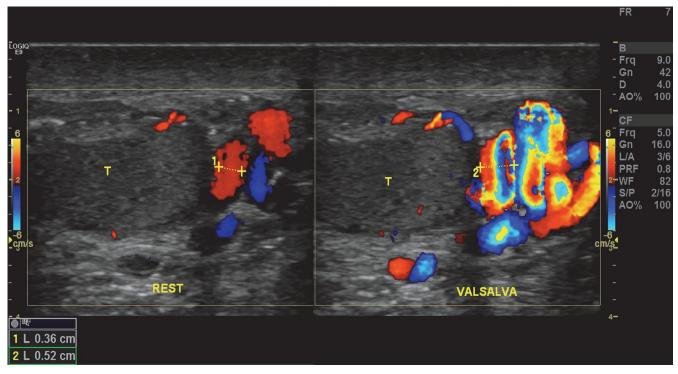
Unilateral (left) varicocele patient with advanced stage, rest and during valsalva maneuver color Doppler sonography view was presented (rest vein diameter 3.6 mm, after the Valsalva maneuver vein diameter 5.2 mm) reflux during valsalva maneuver (T: testis).
